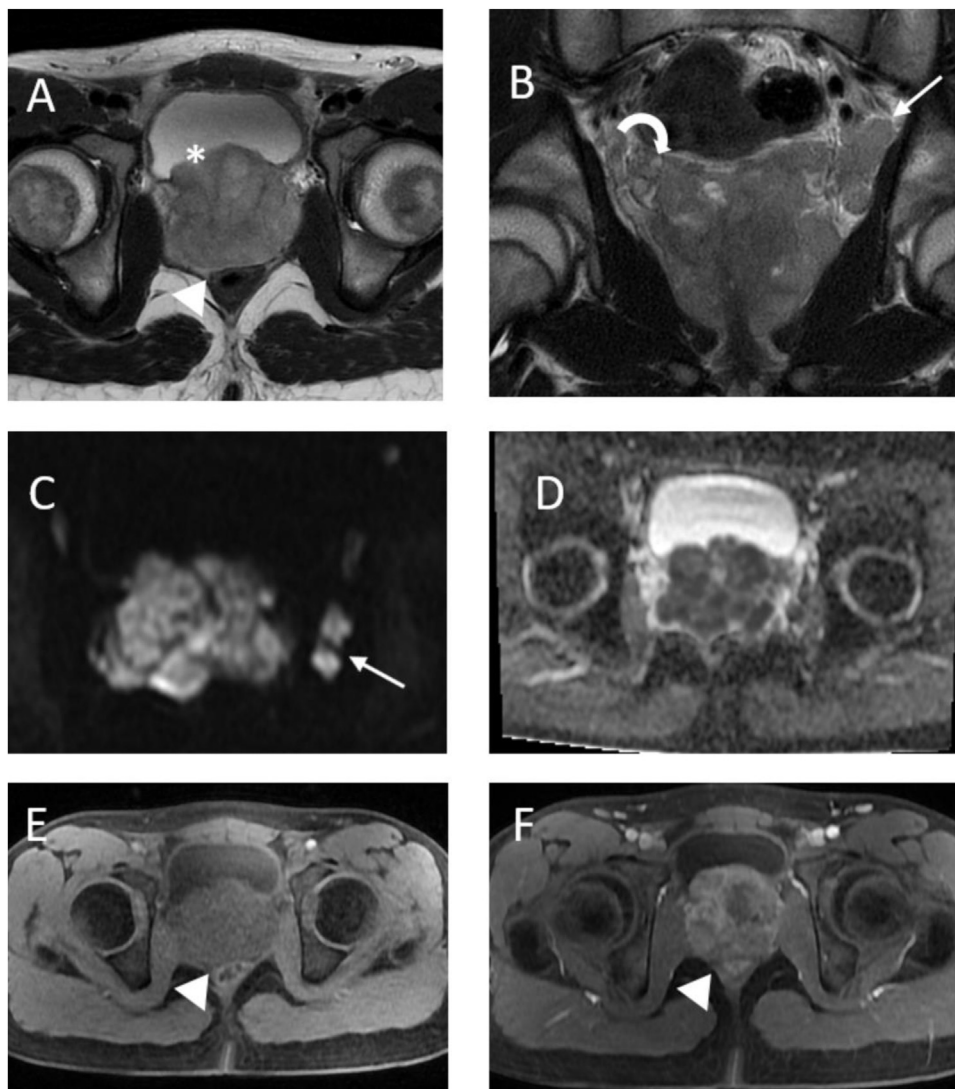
Contrast-enhanced pelvis MRI: (A) axial T2WI, (B) coronal T2WI, (C and D) DWI/ADC, (E and F) T1WI pre- and postcontrast. Enlarged prostate with whole parenchyma is heterogeneous hyper-signal on T2WI (A, B), hypo-signal on T1WI (E), restricted diffusion on DWI/ADC (C and D), postcontrast sequence (F), irregular rough surface, bilateral seminal vesicles invasion (curved arrow) and bladder neck (asterisk) compression and the rectum is pushed backward (triangle—A, E, F). Right external pelvic, left internal pelvic and left inguinal lymph nodes (straight arrow—B, C).
